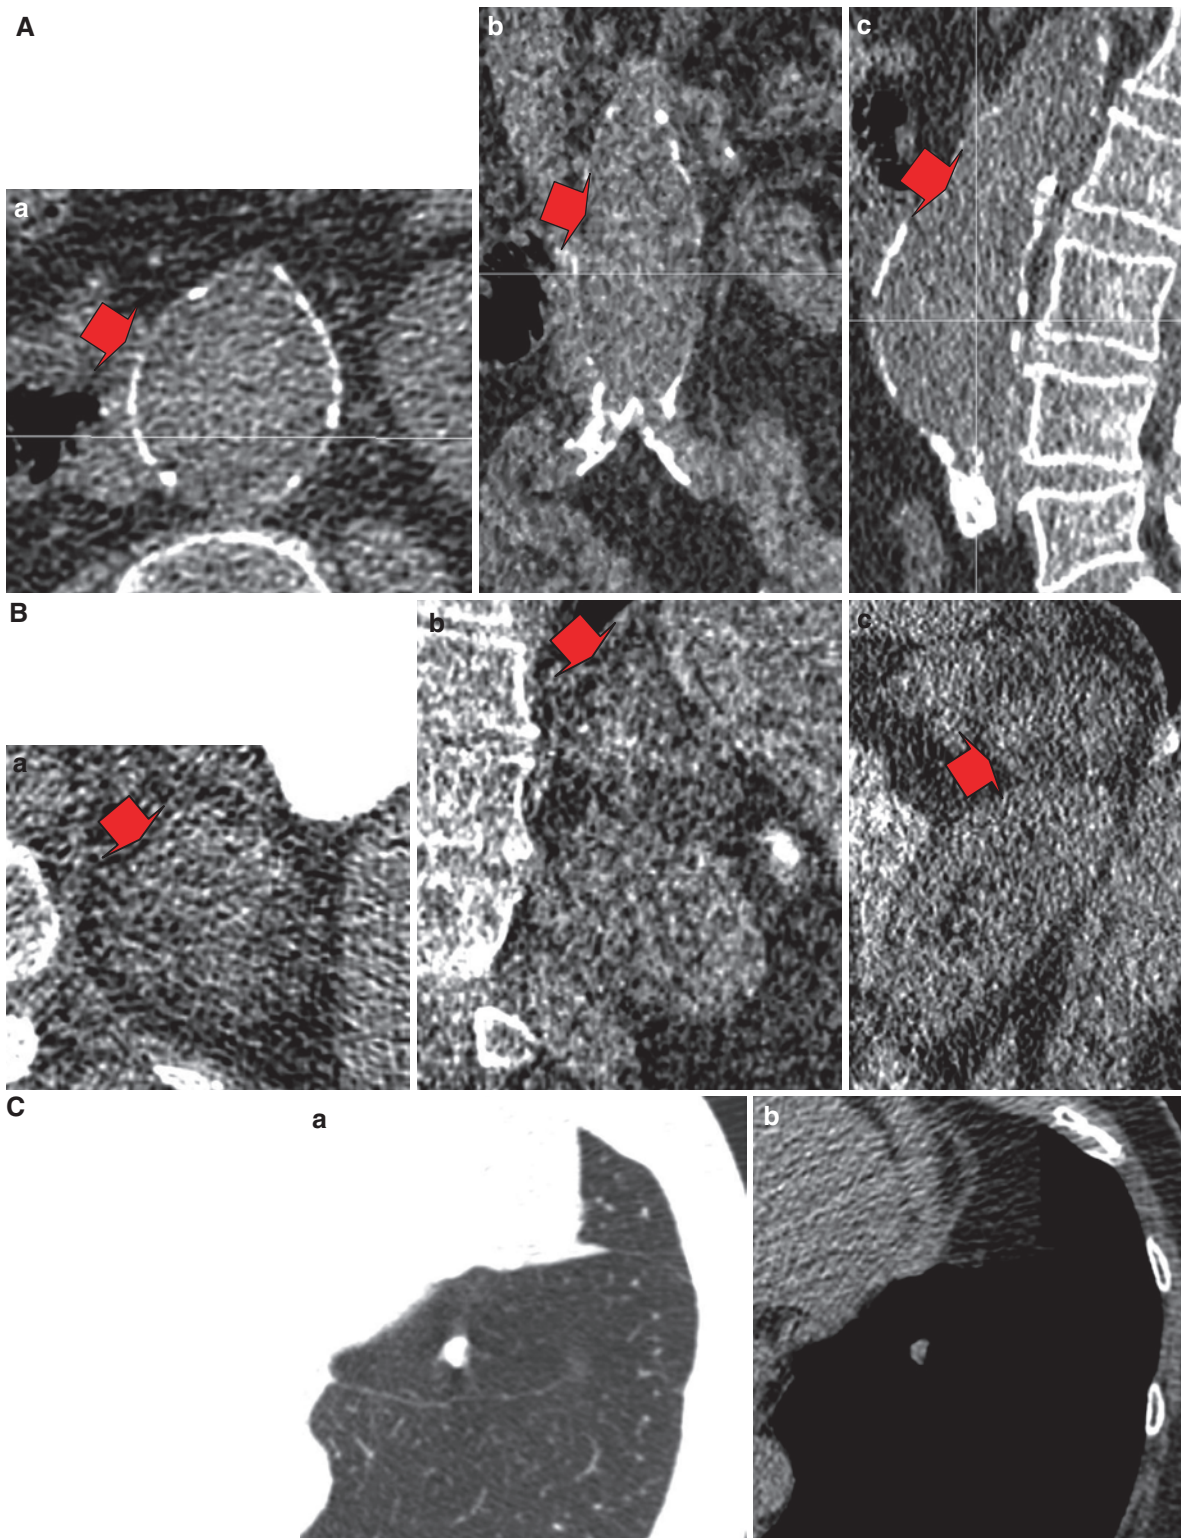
(A) Nonenhanced transverse (a), coronal (b), and sagittal (c) CT scan obtained at 50 mA for CT colonography demonstrate a 35 mm diameter subrenal abdominal aortic aneurysm (*arrow*), which was previously unknown. (B) Non-enhanced transverse (a), coronal (b), and sagittal (c) CT scan
